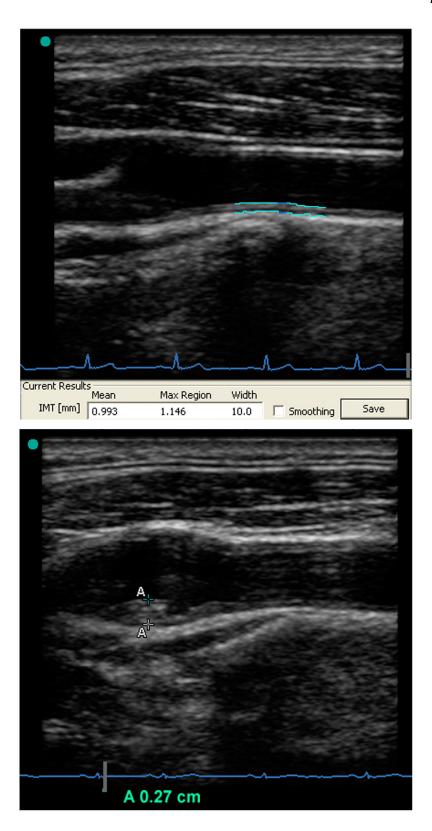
Representative Carotid Ultrasound Images
